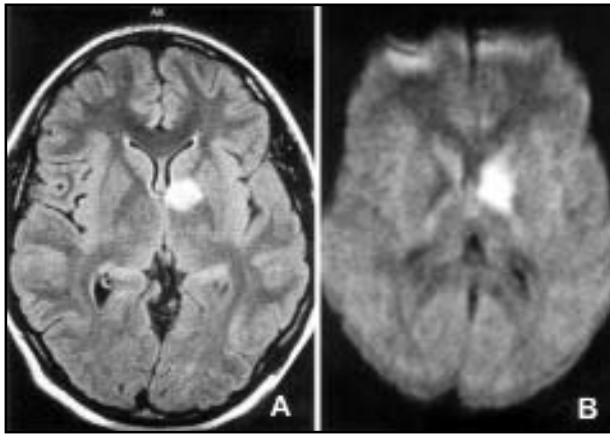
Axial FLAIR MR image demonstrated hyperintense signal in the left caudate nucleus and genu of the internal capsule (A). Diffusion-weighted image suggested acute infarct involving the left lenticulostriate arteries territory (B).
